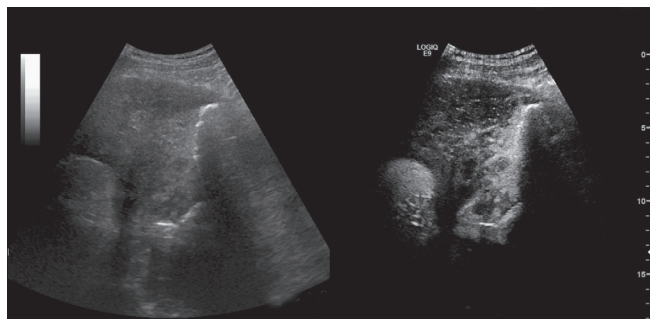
Mediastinal ultrasound using contrast enhanced ultrasound to demonstrate vital Hodgkin's disease by contrast enhancement.
